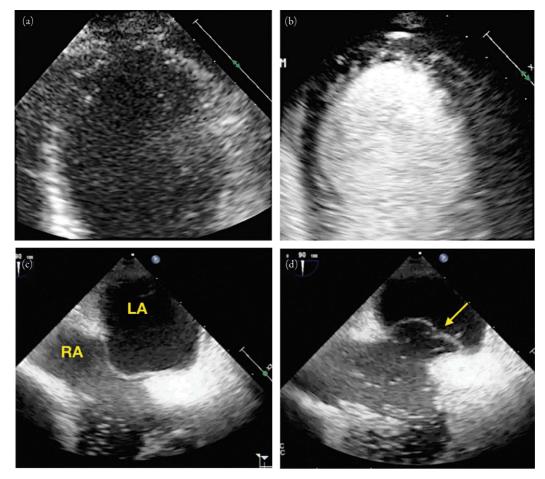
Echo contrast for left ventricular opacification. This is a side-by-side comparison of a left ventricle (LV) with poorly visualized endocardial border (a), and the same LV imaged using a contrast agent (b). The endocardial border is clearly visualized, and there is no evidence of apical thrombus using the contrast agent. Images courtesy of Drs. Anthony Koppula, MD, and Robin Wachsner, MD, Division of Cardiology, Department of Medicine, Olive View—UCLA Medical Center, Los Angeles, CA. Echo contrast to detect patent foramen ovale. The image on the (c) shows a bicaval window on transesophageal echocardiography just after agitated saline is injected. When the patient performs a provocative maneuver (e.g., Valsalva, sniff, or cough) to temporarily increase right-sided pressures, there is bowing of the atrial septum with transmission of microbubbles to the left atrium (d), confirming a patent foramen ovale. Images courtesy of Drs. Anthony Koppula, MD, and Robin Wachsner, MD, Division of Cardiology, Department of Medicine, Olive View—UCLA Medical Center, Los Angeles, CA.
